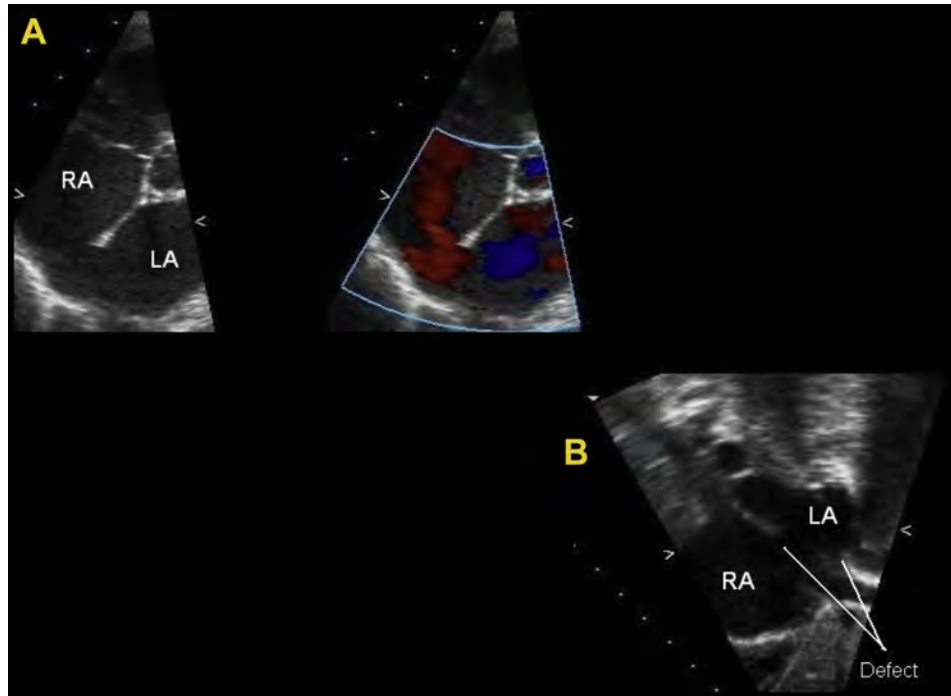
(A) Inferior vena cava type sinus venosus ASD by 2D TTE (*left*) and with color Doppler (*right*) in the parasternal short-axis view with left to right flow. (B) IVC type sinus venosus ASD by 2D TTE in the subcostal view. See also [Video 10](#).
